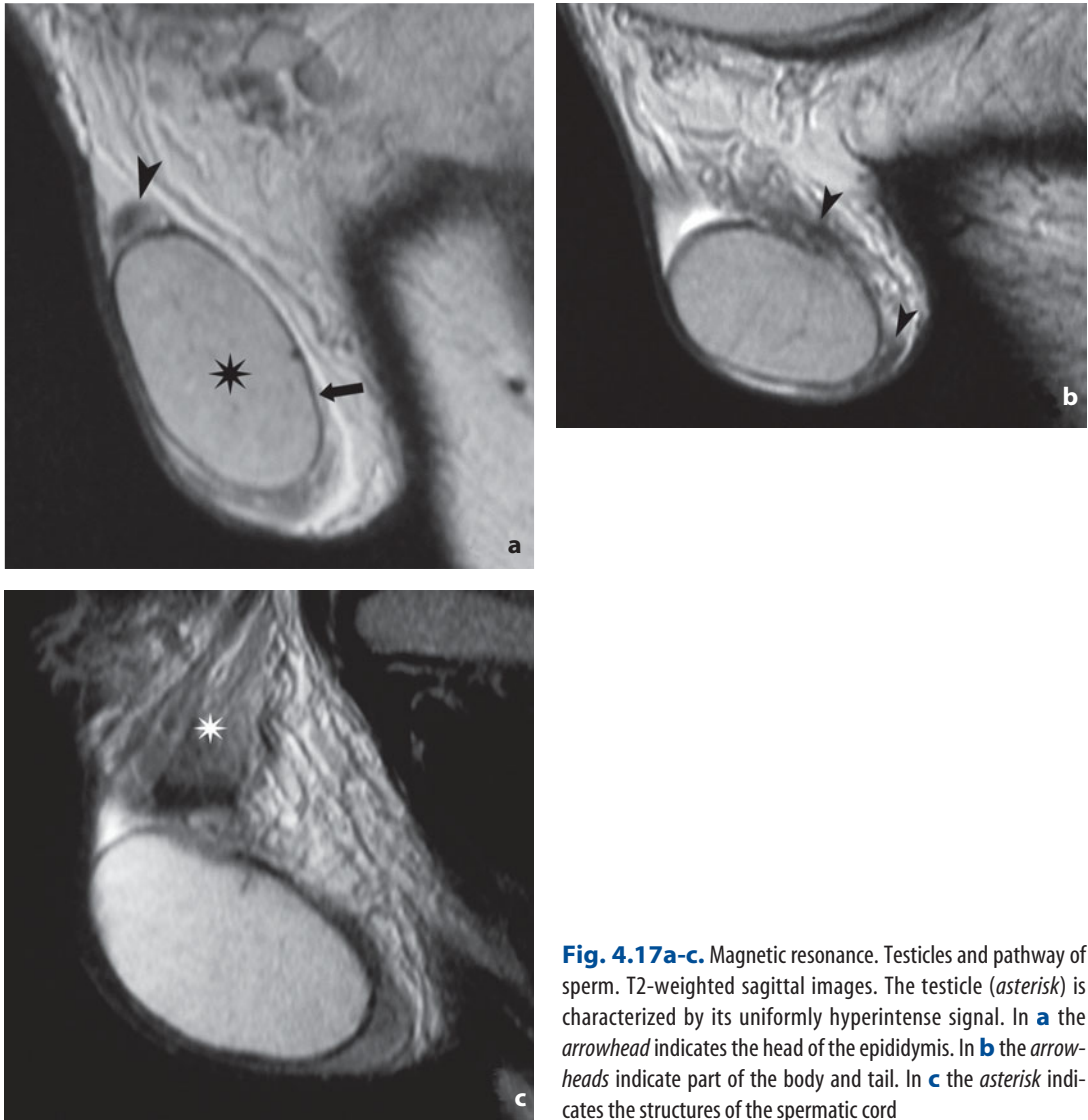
Magnetic resonance. Testicles and pathway of sperm. T2-weighted sagittal images. The testicle (*asterisk*) is characterized by its uniformly hyperintense signal. In a the *arrowhead* indicates the head of the epididymis. In b the *arrowheads* indicate part of the body and tail. In c the *asterisk* indicates the structures of the spermatic cord
